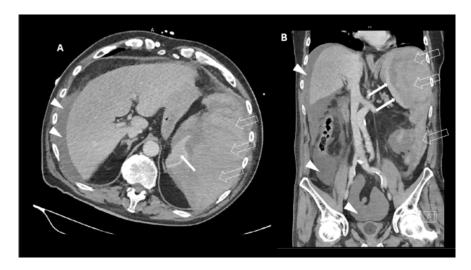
Axial (A) and coronal (B) CT-scan showing subcapsular hematoma (empty arrows), diffuse hemoperitoneum (arrow heads) and residue or the ruptured spleen (full arrows).
